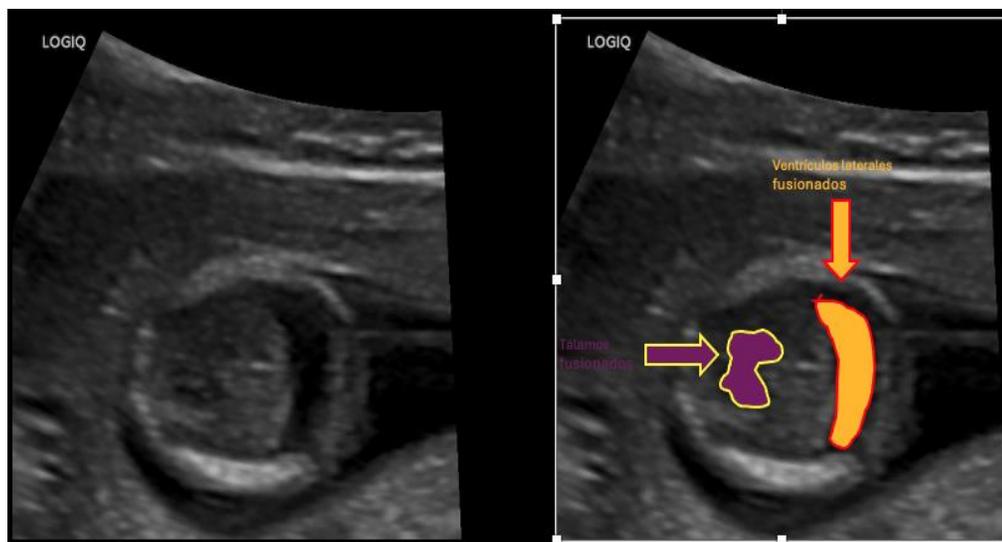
Fetal ultrasound. Transthalamic axial view.
